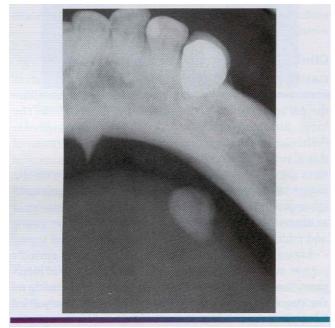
13 • Sialolit hiasis. Occlusal radiograph demonstrating radiopaque stone in Wharton's duct.
